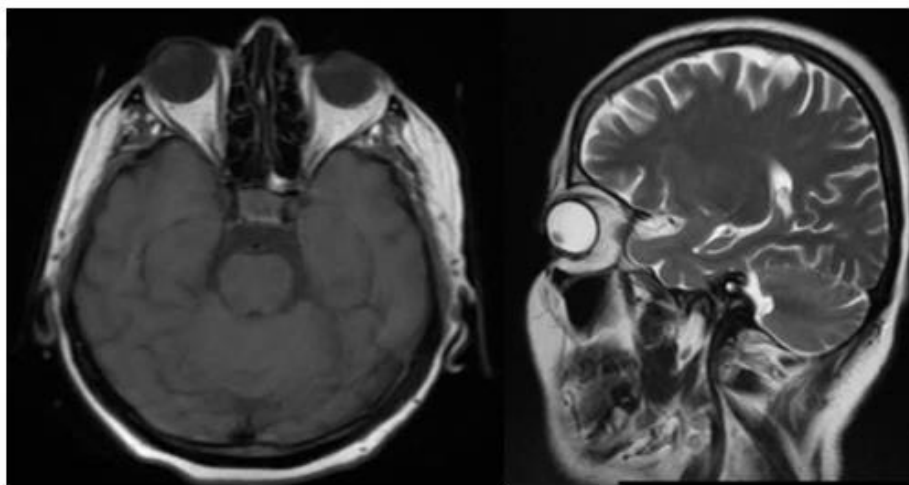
Brain MRI demonstrating no evidence of cerebellar metastasis or structural lesion at the time of neurological symptom onset.
